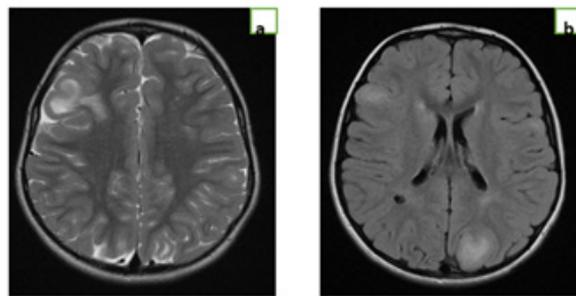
Axial cut MRIT2(a), FLAIR(b)showing multiple cortical ranges of the white substance sus ten-torial in), FLAIR (hypo signal T1, hypersignal T2(a)and FLAIR (bb) without restriction of diffusion and without taking pathological contrast correspondent to corsical tubers.
